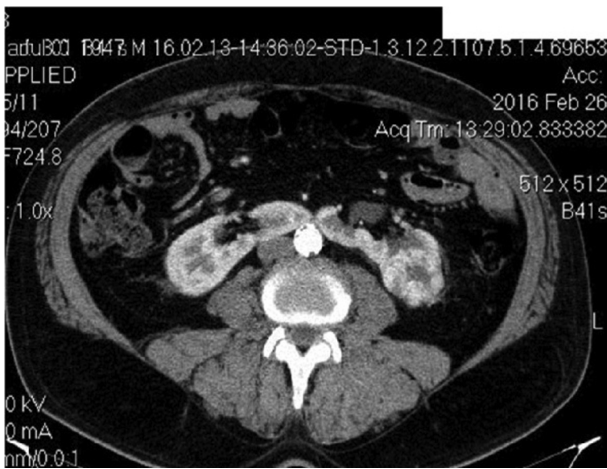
Axial contrast-enhanced abdominopelvic CT showing a 48-mm lower-pole mass in the left moiety of the horseshoe kidney.
